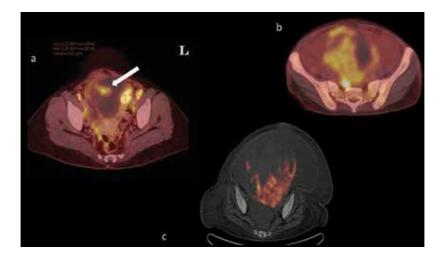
PET/CT scans in axial view demonstrating malignant ovarian tumours. White arrow shows markedly increased FDG uptake within the solid component of the tumour.
